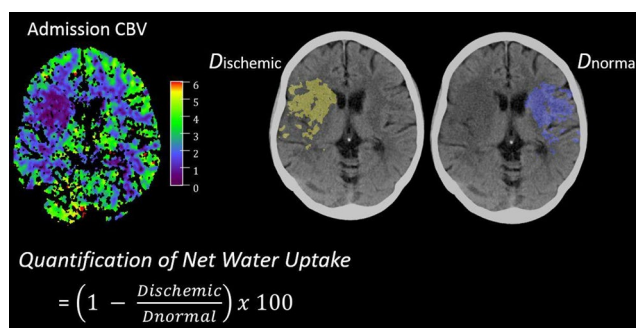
CT segmentation for quantitative image analysis. Infarct lesion was defined by CBV decrease on admission CT. The infarct lesion was segmented and mirrored to obtain measurements of infarct density (Dinfarct in yellow) and contralateral normal tissue (Dnormal in blue) and further Net Water Uptake calculation as shown in the equation. (modified from Broocks et al. Investigative Radiology 2018)
